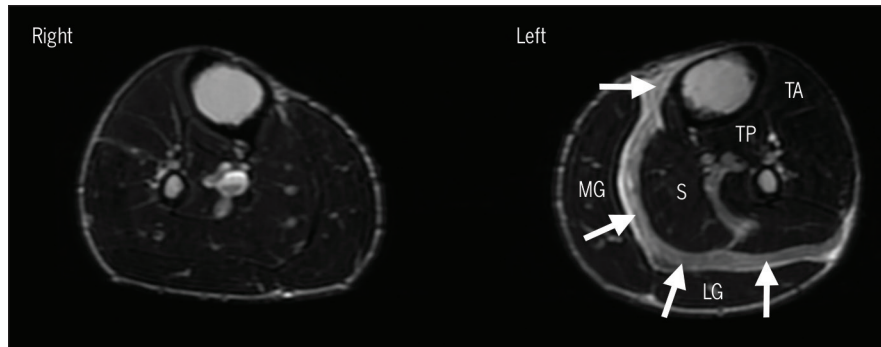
Initial (day 1 post injury) T2-weighted, axial magnetic resonance imaging (fast recovery, fast spin-echo) image. The white arrows represent edema. Abbreviations: LG, lateral gastrocnemius; MG, medial gastrocnemius; S, soleus; TA, tibialis anterior; TP, tibialis posterior.
